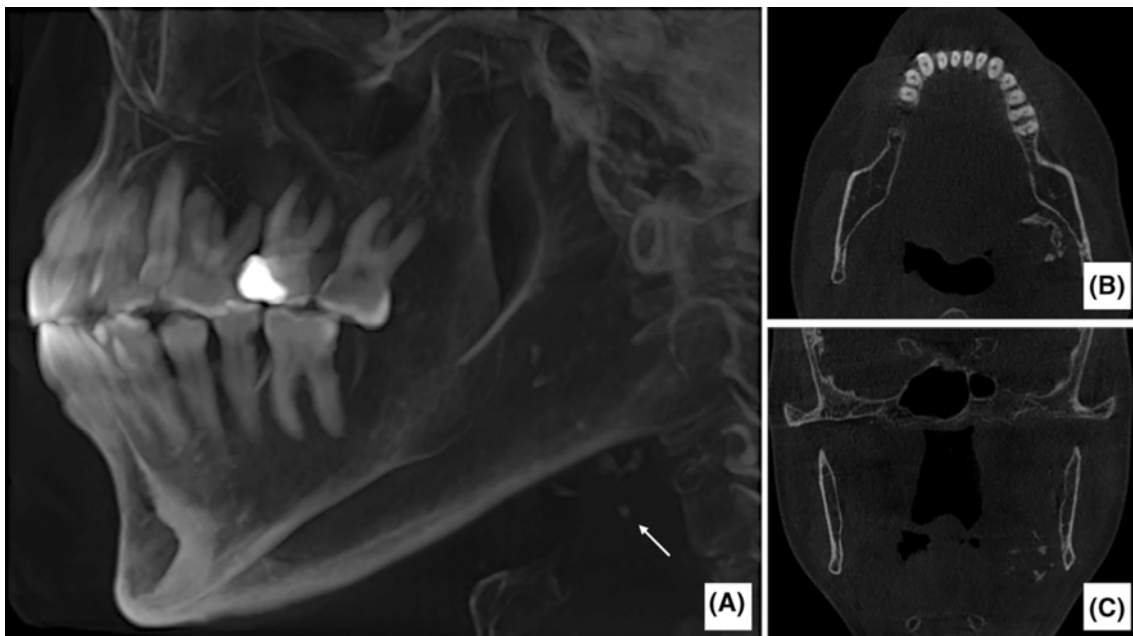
(A) Three-dimensional reconstructed, (B) axial and (C) coronal CBCT images of Case 2 showing circular calcifications involving the lingual surface of the left ramus corresponding to the site of the submandibular salivary gland.
